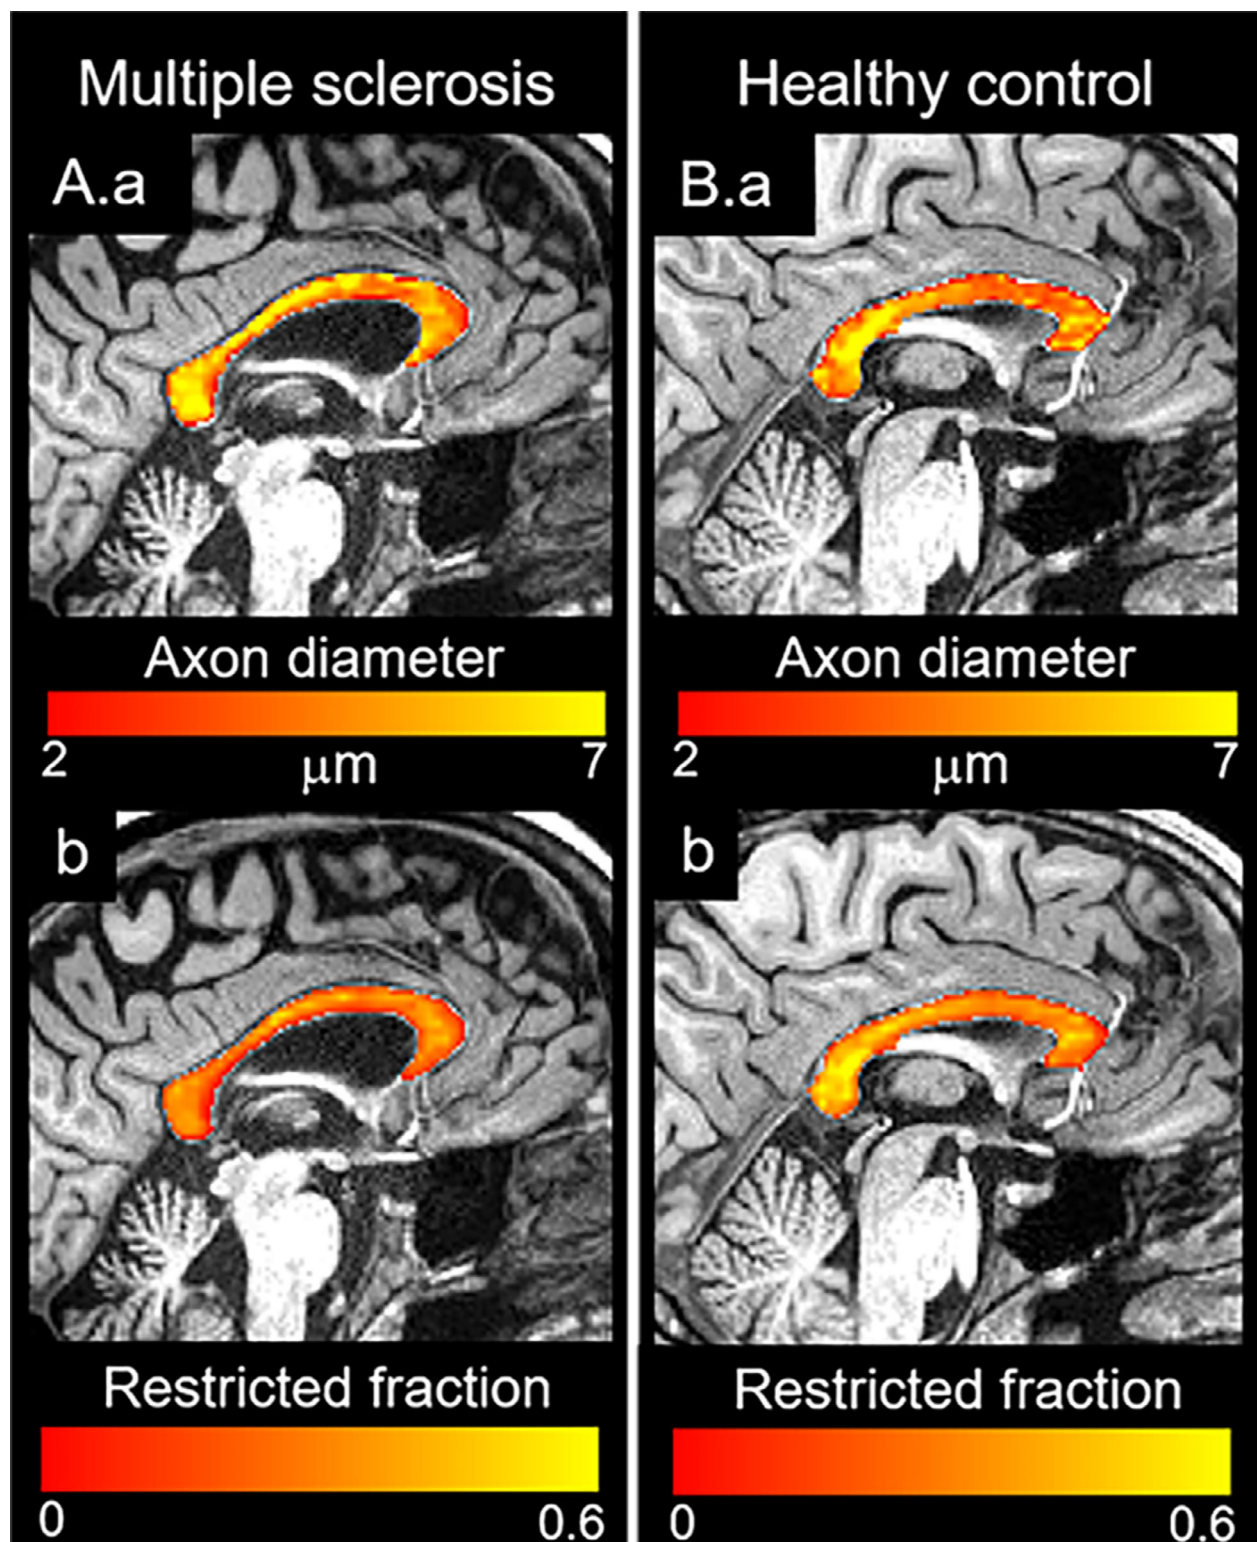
Axon diameter and restricted volume fraction maps in the corpus callosum using high-gradient diffusion MRI. Sagittal axon diameter and restricted volume fraction maps in the midline corpus callosum show diffusely increased axon diameter and decreased restricted fraction in a patient with multiple sclerosis (A.a and b) compared to an age-matched healthy control (B.a and b).
